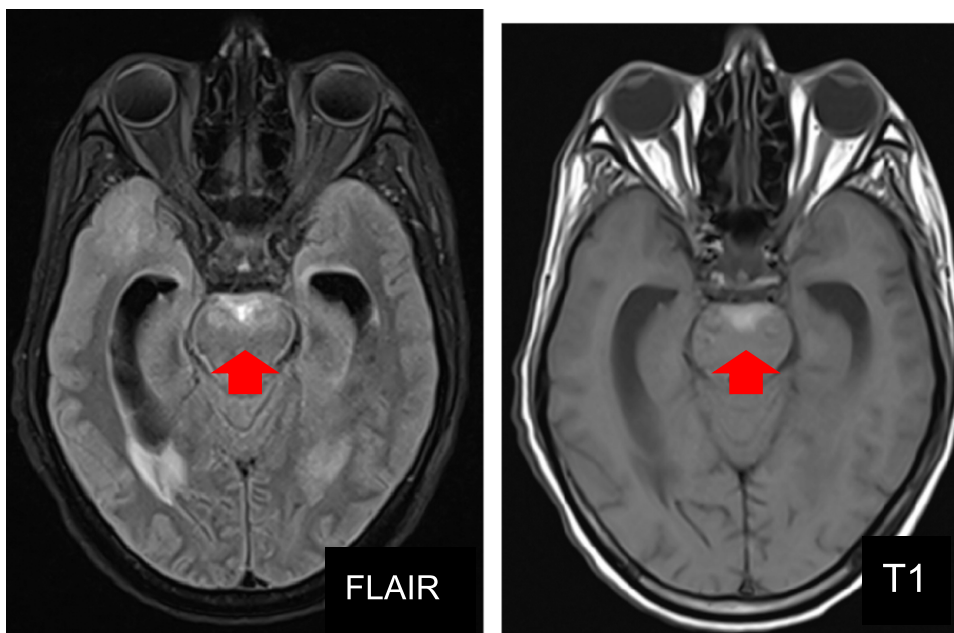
T1 and FLAIR hyperintensity is noted at the interpenduncular cistern to suggest basal exudates.
